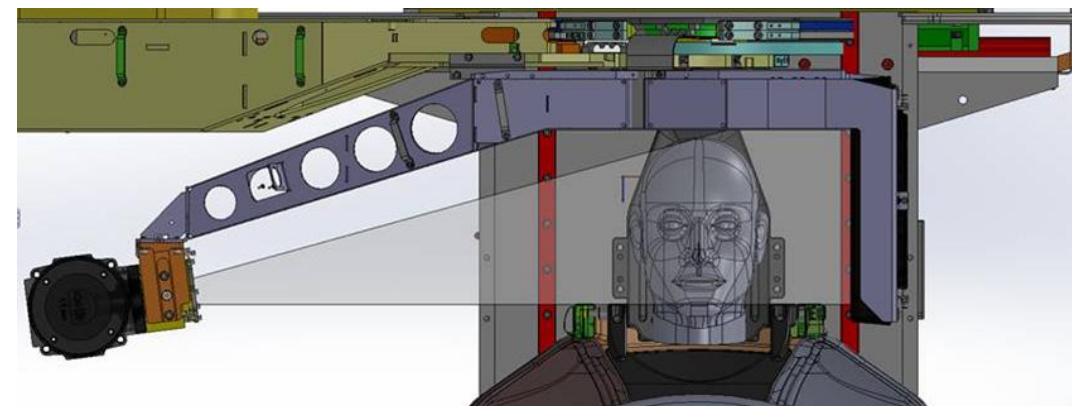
The X-ray field is aligned with the frame fixation
